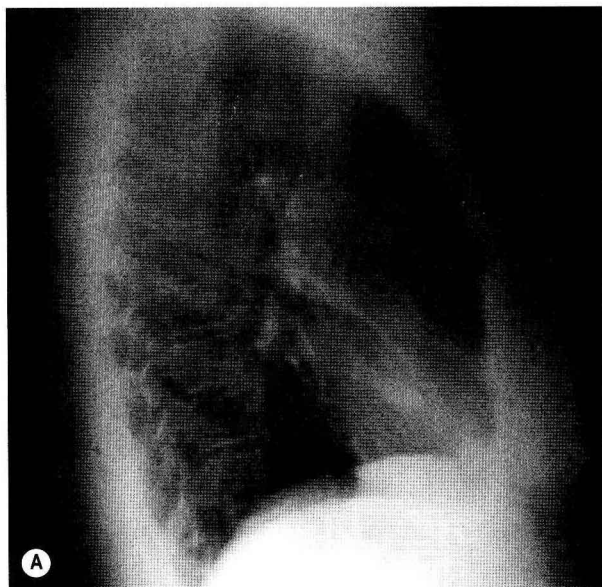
Normal lateral chest X-ray.
